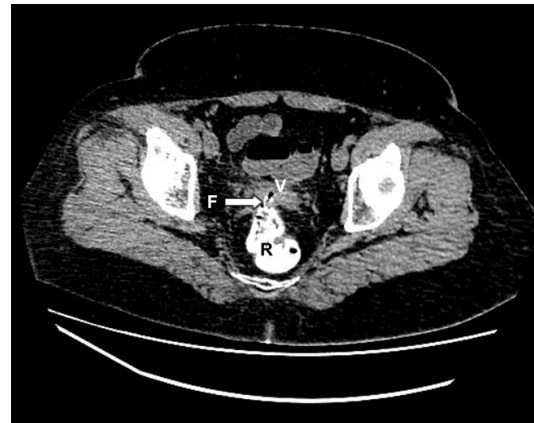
CT imaging of rectal perfusion in horizontal plane indicated contrast agent flowing into vaginal through the fistula at anterior rectal wall (arrow). V, vaginal; R, rectum; F, fistula.
